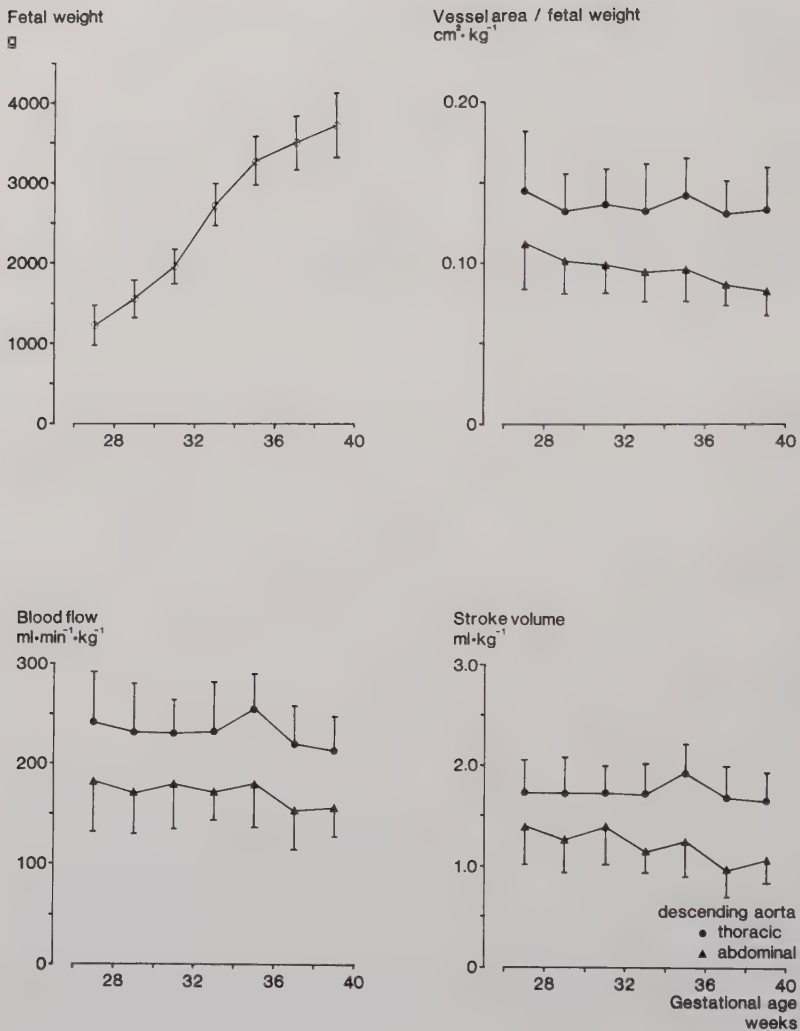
Changes with gestational age of the ultrasonically estimated fetal weight and weight-related cross-sectional vessel area, blood flow and stroke volume measured in the descending thoracic and abdominal aorta of normal fetuses (Mean $\pm$ SD; n = 21).
